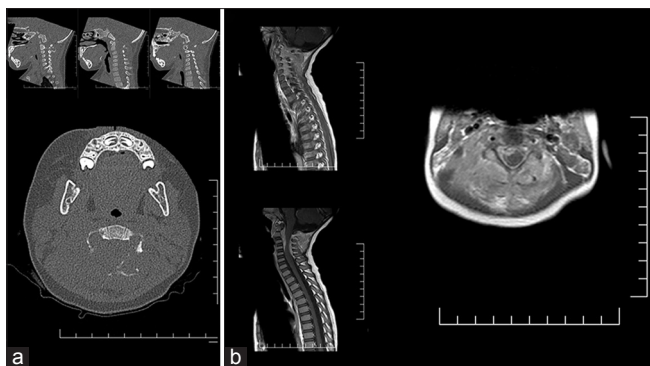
Images for the patient in case 1. (a) Computed tomography of the cervical spine without contrast. Sagittal (top) and axial (bottom) images. (b) Magnetic resonance imaging of the upper spine with contrast. Sagittal (left) and axial (right) images
